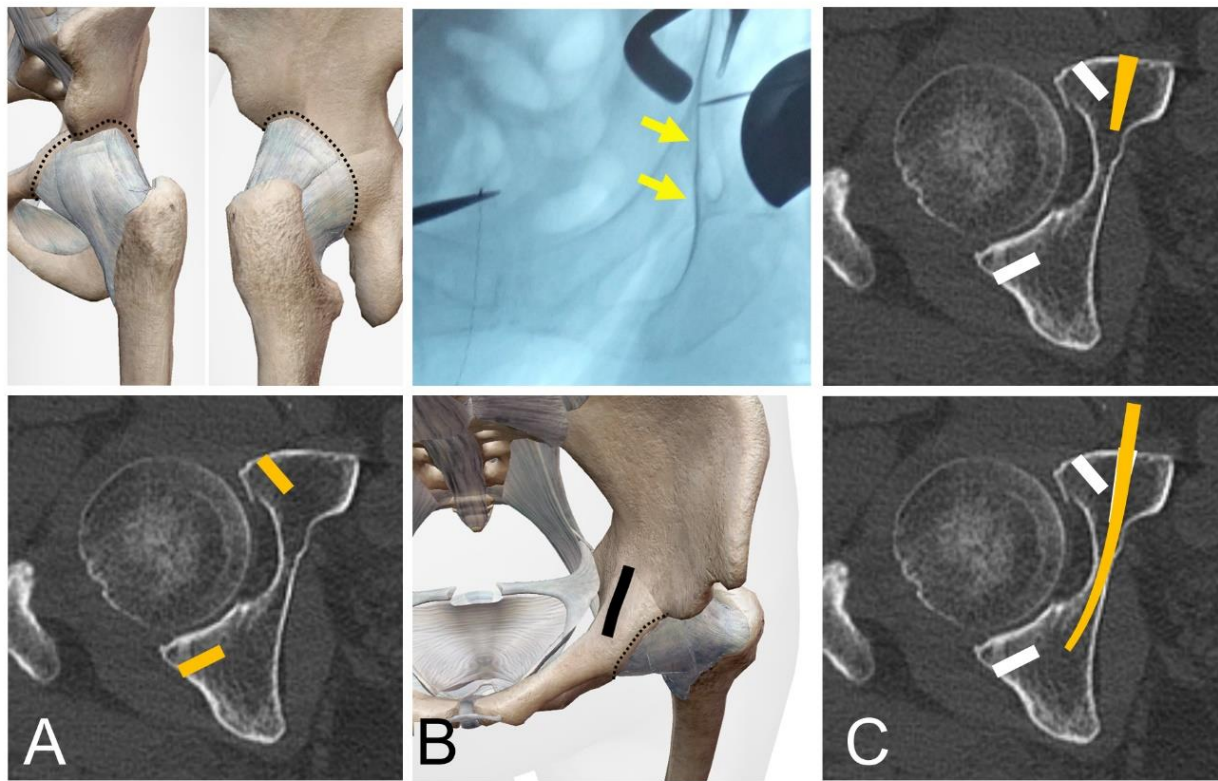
The acetabular cut lines (dotted lines, A-top) are determined using radiography or navigation, and the cortical bone is cut to a depth of 15 mm (orange lines, A-bottom). Fluoroscopic imaging was used to identify the alignment of the Köhler line and the medial teardrop line (yellow arrows, B-top). A fenestration hole is made at the medial acetabular column (black line, B-bottom). A blunt straight chisel is inserted into the bottom of the acetabulum (orange line, C-top). A thin-bladed curved chisel is used to separate the acetabular bottom from the medial cortex of the pelvis (orange lines, C-bottom) (Visible Body Suite, Argosy Publishing, Inc., USA)
